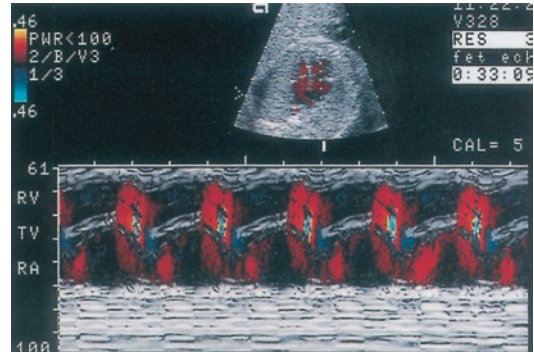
Color M-mode sonogram. *Top*: Two-dimensional color Doppler echocardiogram of the fetal heart (four-chamber view). M-mode cursor is indicated by the *dotted line*. *Bottom*: Color M-mode tracing of flow from the right atrium (RA) to the right ventricle (RV) across the tricuspid orifice. The movement of the tricuspid valve (TV) is visible in the *middle* of the panel. As the flow is toward the transducer, it is coded *red*. Note the aliasing at the tricuspid orifice level (*blue and yellow*)
